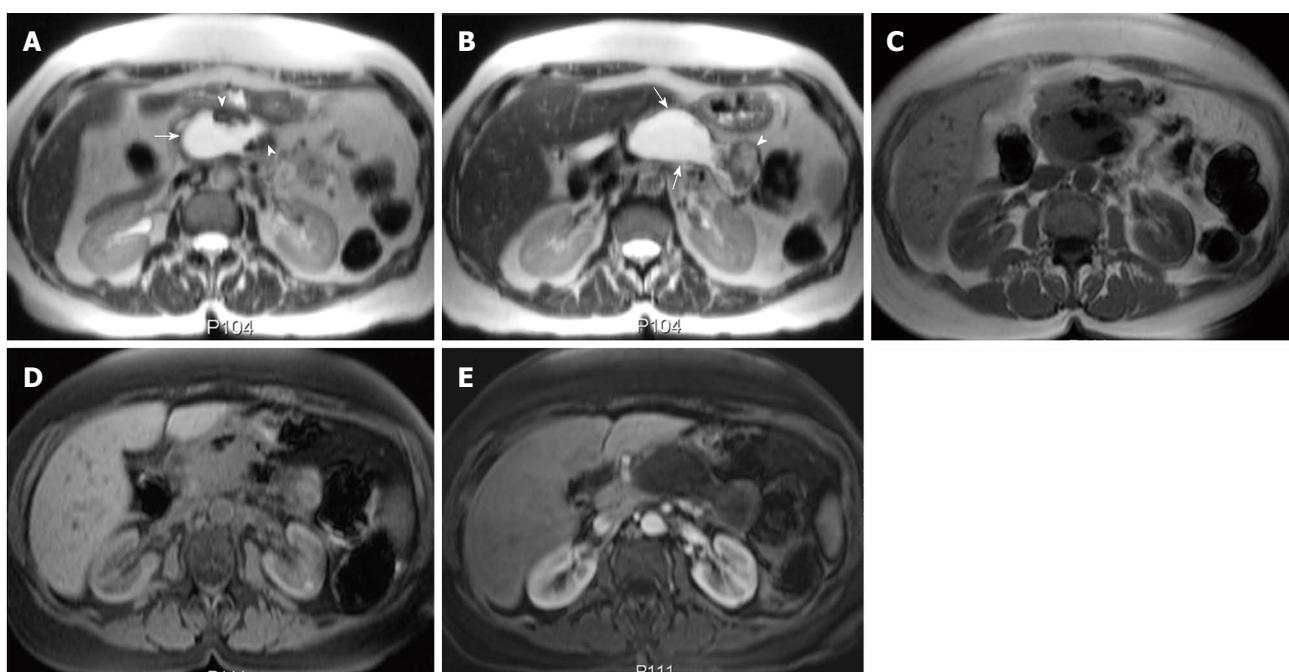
Acute necrotic collection. A, B: Axial single-shot turbo spin-echo T2-weighted (HASTE) image; C: Axial fast low-angle shot (FLASH) in-phase T1-weighted image; D: Axial FLASH in-phase T1-weighted image with fat-suppression; E: Axial post-Gadolinium 3D-GRE T1-weighted image with fat-suppression during the hepatic arterial-dominant phase. There is a well-defined fluid collection (arrows) replacing a great portion of the pancreatic parenchyma and extending into the peripancreatic tissue, associated with few internal areas of decreased T2 signal intensity (arrowheads) (A); which do not show any appreciable enhancement (B, C) in keeping with acute necrotic collection.
